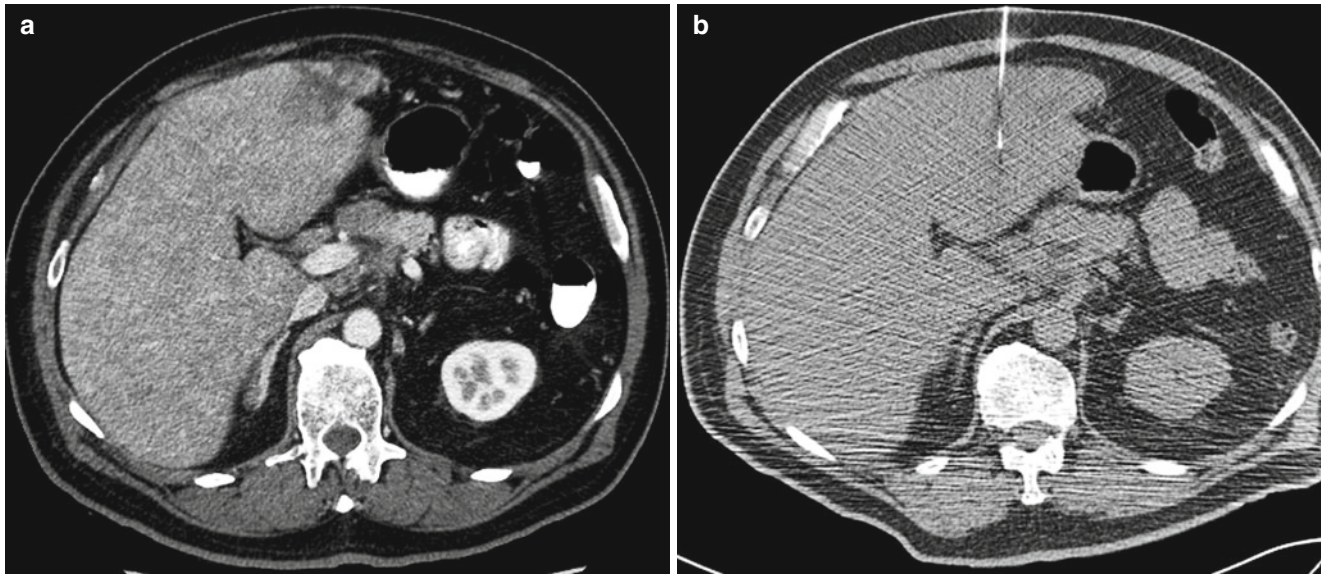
A 65-year-old man with history of Merkel cell carcinoma was referred for liver biopsy. Diagnostic axial CT image of the abdomen after administration of contrast (a) shows a lesion in segment II of the liver. A noncontrast axial CT image of the abdomen (b) at the time of biopsy did not clearly show the tumor. The lesion was targeted by anatomic landmarks. Immediate assessment of the FNA samples by
